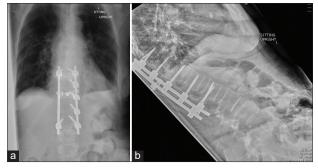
(a) Postoperative upright thoracic spine AP X-ray showing good hardware construct utilizing five screws on the left and two screws on the right. (b) Lateral plain film showing good sagittal alignment and disc spacing.
